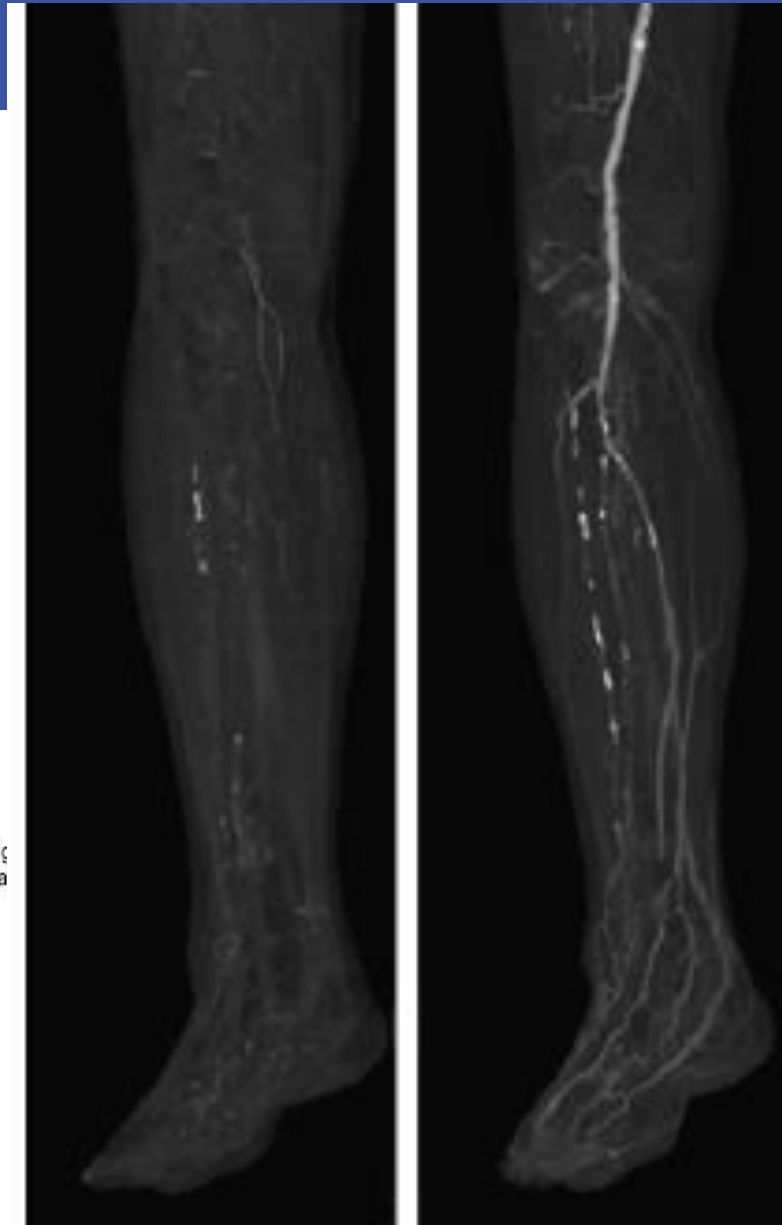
CT angiography findings that were taken before and after successful PTA. PTA was performed on the right femoral, peroneal, and posterior tibial arteries in this patient.
